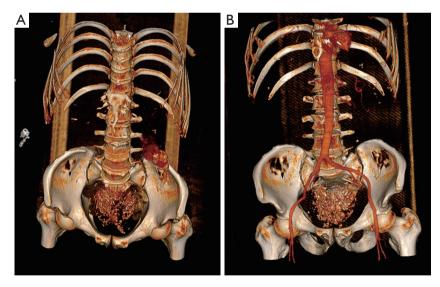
The three-dimensional reconstruction of the enhanced CT. (A) The CT three-dimensional reconstruction of pelvic SFT. (B) The CT three-dimensional reconstruction of pelvic SFT arteries. CT; computed tomography; SFT, solitary fibrous tumor.
